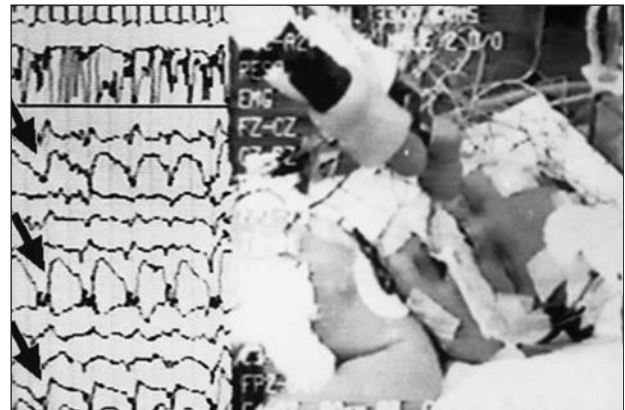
Segment of a video EEG for a fullterm infant born to a 45-year-old prima gravida female who suffered severe preeclampsia. No thrombophilia was documented, although significant placental infarction was noted. The child presented with a neonatal encephalopathy, including seizures. This EEG segment documents persistent electrical seizures without clinical signs (arrows), despite multiple antiepileptic medications, while the patient was pharmacologically paralyzed for ventilatory control. 4b: CT scan of brain for the patient in 4a, documenting multifocal infarctions, as a result of both presumed thrombophilia, which also caused placental infarction as well as hypoperfusion-induced injuries from asphyxia, secondary to maternal preeclampsia.
